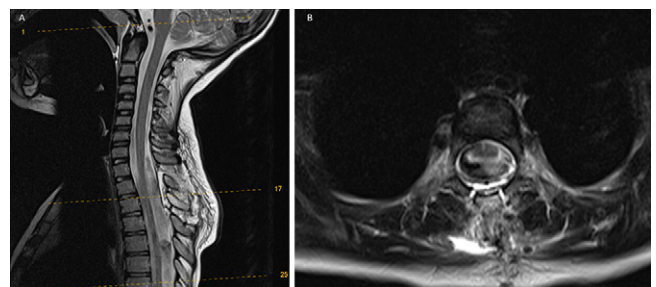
Postoperative MRI of the spine, demonstrating fenestrated arachnoid cyst with decompressed spinal cord. A: Sagittal T2-weighted image. B: Axial T2-weighted image.
